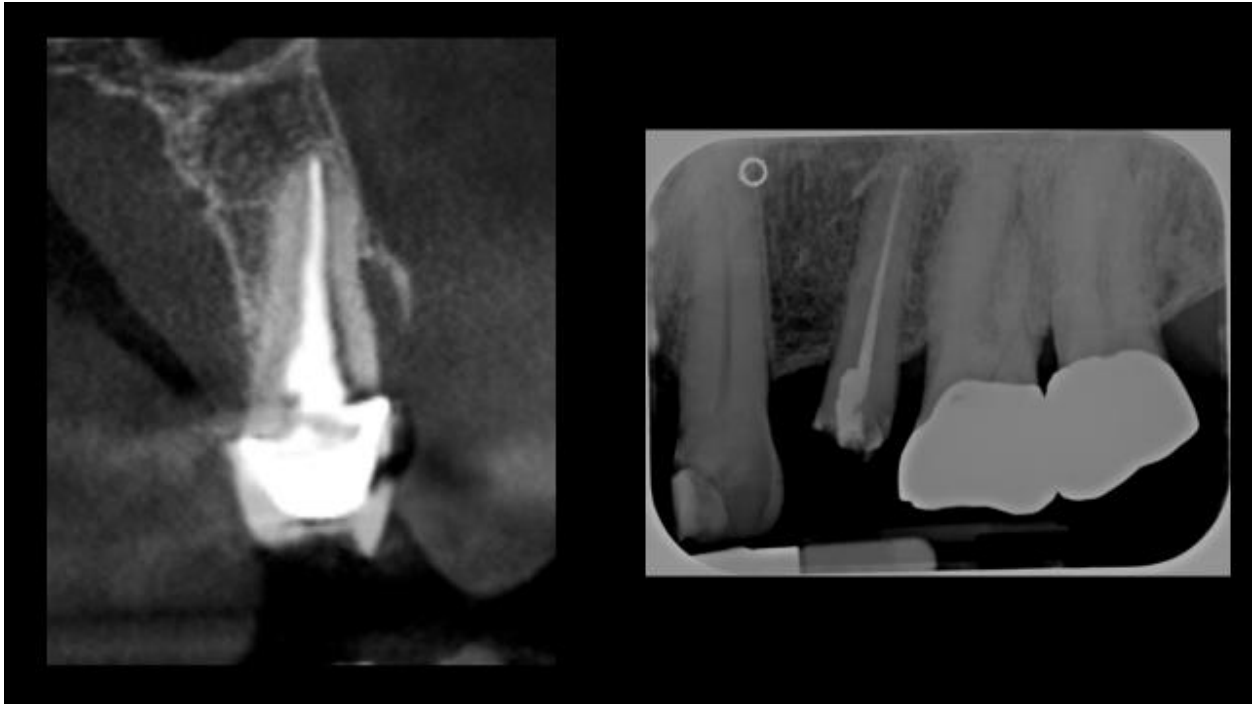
Buccal vertical defect #13 CBCT (left) not visible on PA (right)
